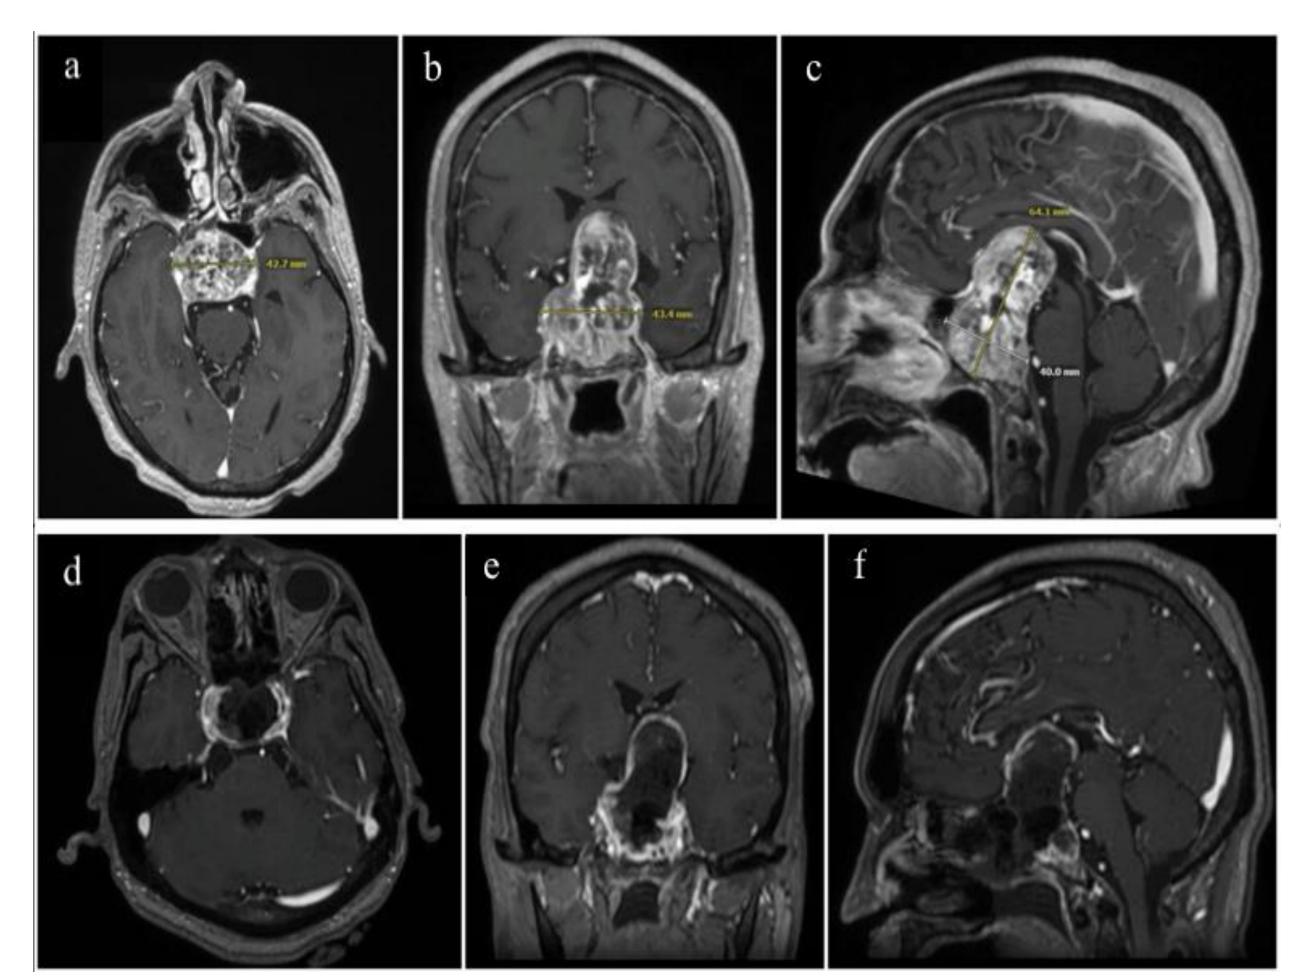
Preoperative (a, b and c) and postoperative (d, e and f) Brain MRI for Case 1.
